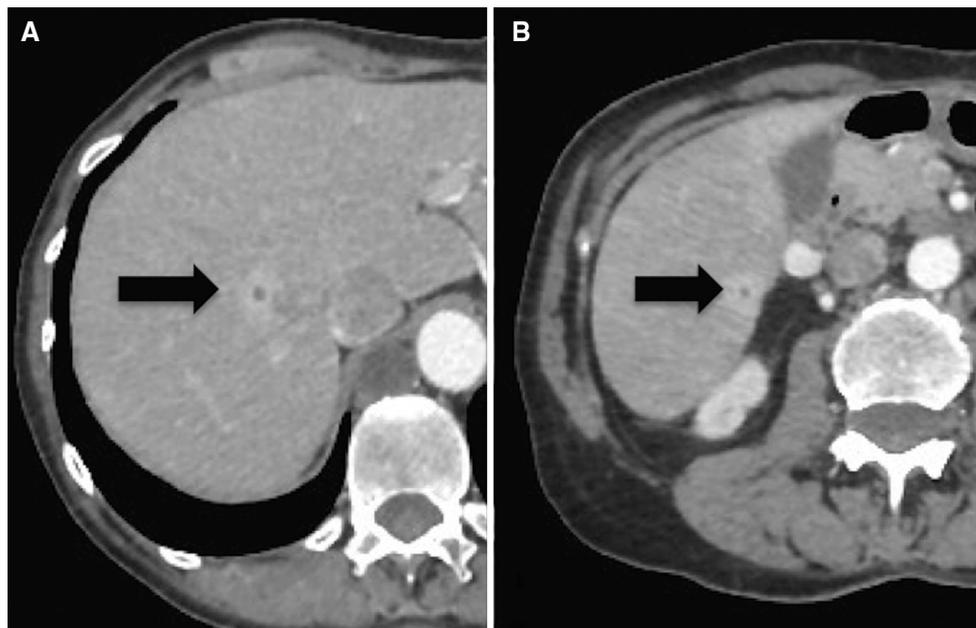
CT scan in arterial phase at 3 weeks post-embolization confirmed lack of enhancement of the previously treated lesions. The patient's symptoms were controlled at this stage
